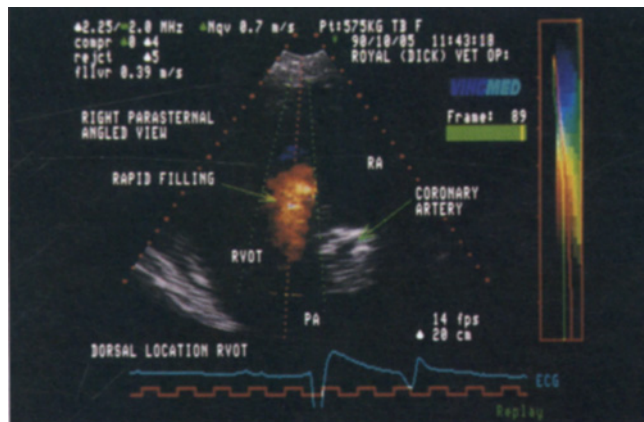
Colour flow study from the right parasternal angled view, dorsal location right ventricular outflow tract. Flow is coded red, moving towards the transducer (top of image), during diastole. A central core of higher velocity flow is coded in lighter shades of red.
